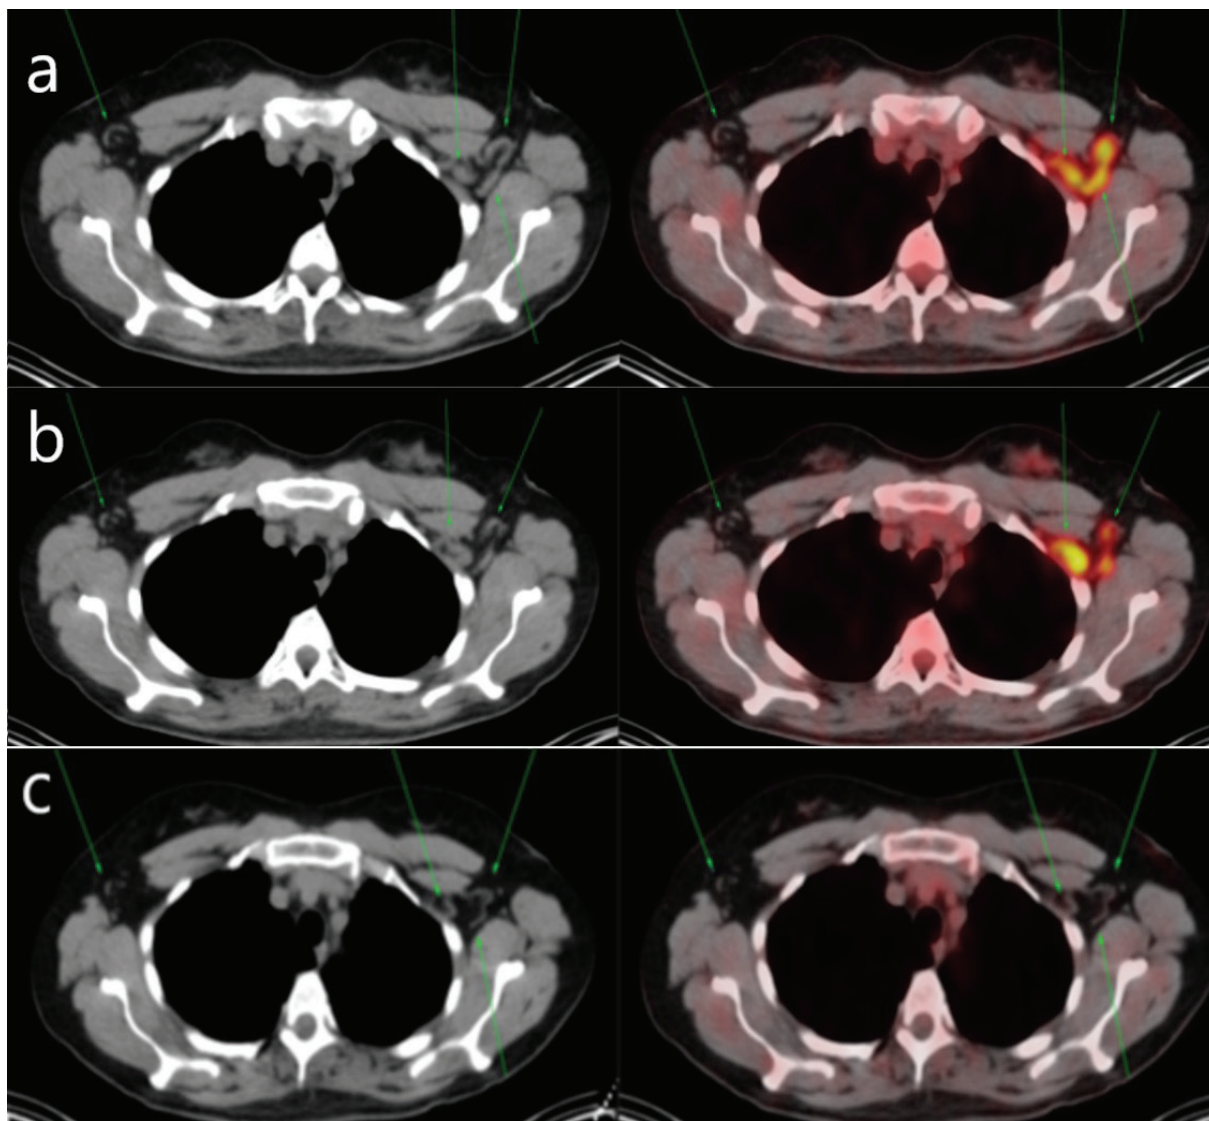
Hybrid images of ^{18}F -FDG PET/CT scanning performed for staging at the beginning (a, b). Initially, no pathological ^{18}F -FDG uptake was observed in lymph nodes that seemed inactive (non-metabolic) in the right axilla. However, there were hypermetabolic lymph nodes in the left axilla and left deep axilla ($\text{SUV}_{\text{max}}: 8.0$). On CT images of the same ^{18}F -FDG PET/CT scanning, the lymph nodes in the right axilla had fatty hiluses and thin walls, whereas the hypermetabolic lymph nodes in the left axilla and left deep axilla had fatty hiluses and thick walls ($\text{SUV}_{\text{max}}: 8.0$) (a, b). At the second ^{18}F -FDG PET/CT imaging after neoadjuvant chemotherapy, the lymph nodes in the left axilla were reduced in size and their ^{18}F -FDG uptake was markedly decreased. Yet, the ones in the right axilla stayed stable (c). At the initial imaging, active and inactive lymph nodes are seen together (a, b). The active to inactive transformation of the lymph nodes after vaccination has been visualized (a, b, c).
